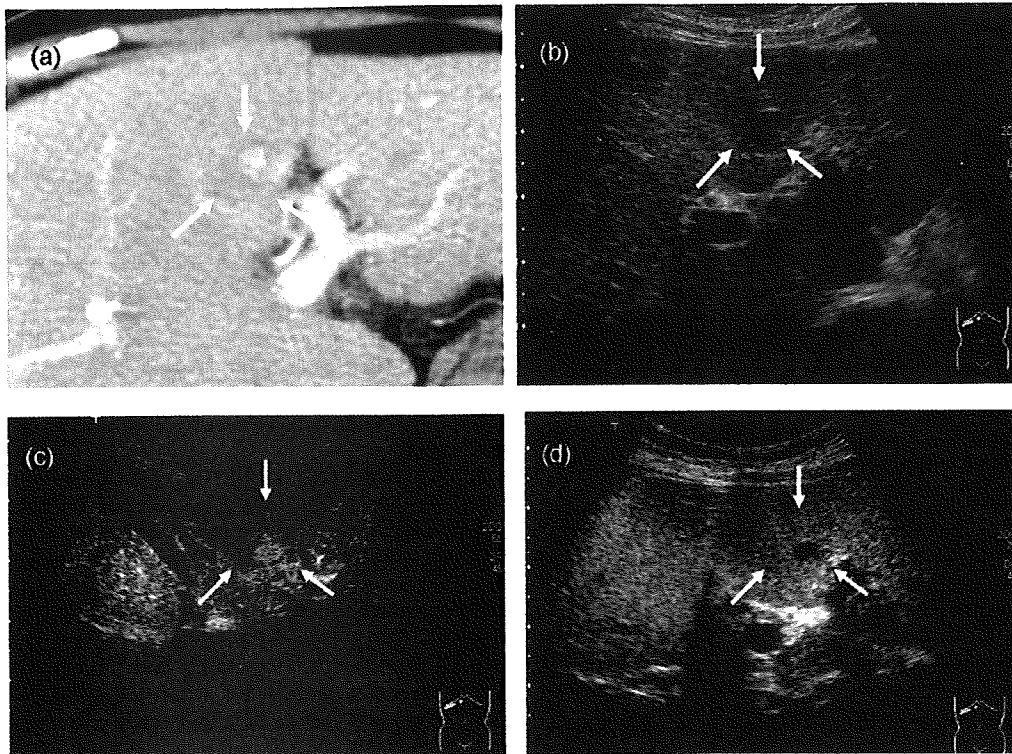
A 69-year-old female, hepatitis C virus-related cirrhosis, HCC with nodule-in-nodule appearance (S4, 24 mm; case 1). (a) Contrast-enhanced CT, artery-dominant phase. HCC with hypovascular outer nodule and hypervascular inner nodule (arrows). (b) Grey-scale US. HCC with hypoechoic appearance (arrows). (c) Contrast-enhanced US, vascular phase. HCC with hypo-enhanced outer nodule and hyper-enhanced inner nodule (arrows). (d) Contrast-enhanced US, late phase. HCC with iso-enhanced outer nodule and hyper-enhanced inner nodule (arrows).
